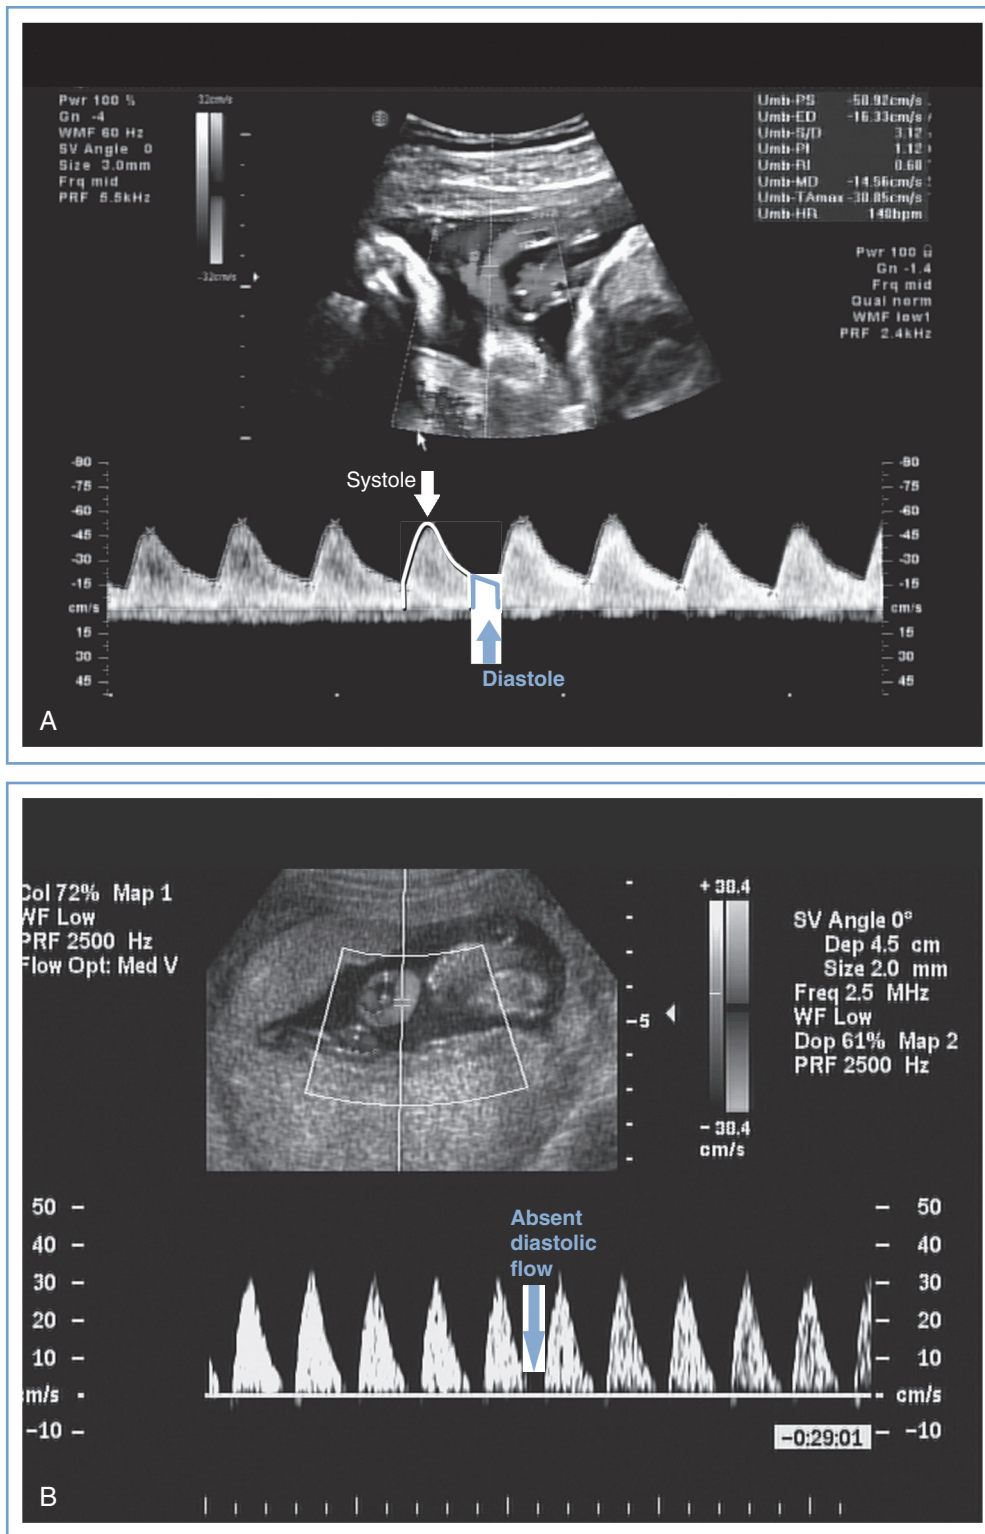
■ Umbilical artery Doppler velocimetry. A, Normal waveform in the umbilical artery as shown on Doppler velocimetry. Forward flow can be seen during both fetal systole and diastole. B, Absent end-diastolic flow. Forward flow can be seen during systole, but there is no flow during diastole.
